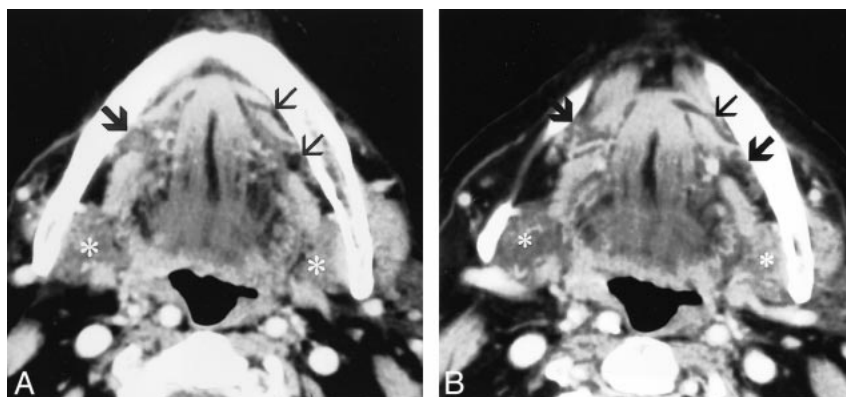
Postcontrast axial CT images through the oral cavity showing multiple mylohyoid muscle defects. Image *A* is cranial to image *B*. On the patients left side, there are two mylohyoid muscle defects. On the right, there is one defect. Accessory salivary tissue is identified bilaterally (large arrows). Note that the accessory salivary tissue has the same attenuation as that of the normal submandibular glands (*). *A*, large arrow, accessory salivary tissue; small arrows, fat-containing defects. *B*, large arrows, accessory salivary tissue; small arrow, fat-containing defect (18).
